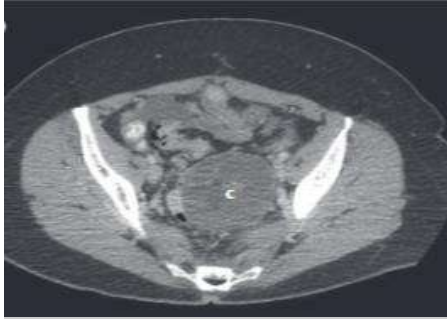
Common finding of an ovarian cancer mass on a CT scan denoted by the letter 'C' [5].
